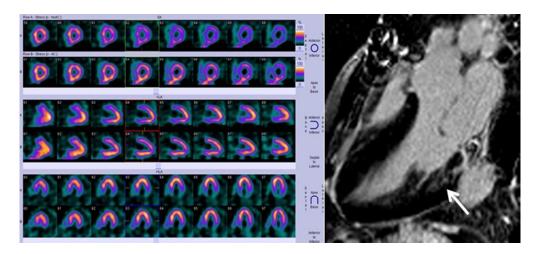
Single photon emission computed tomogram demonstrating abnormal stress perfusion in a patient with LVH and normal coronary arteries.
